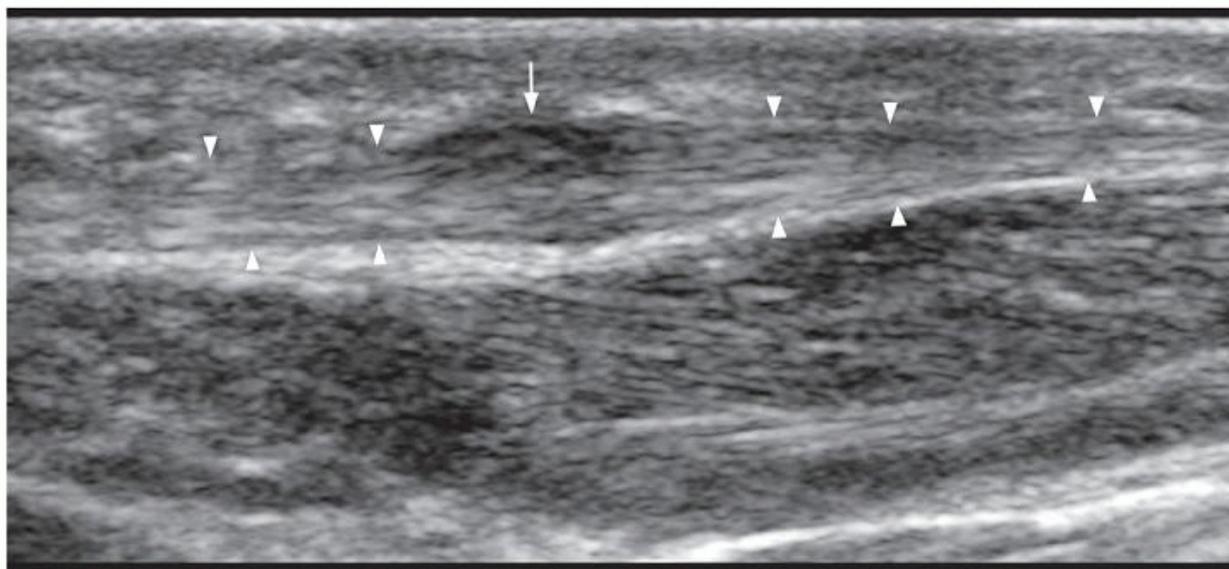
Longitudinal ultrasound of plantar aspect of foot showing medium-sized plantar fibroma (arrow) seen as fusiform, slightly hypoechoic swelling along the plantar fascia (arrowheads).
